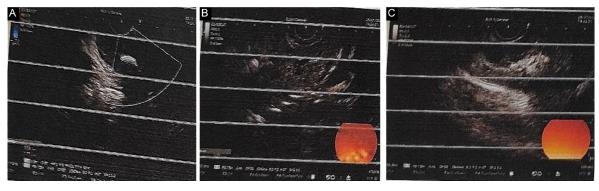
Endoscopic ultrasound report: Caroli's disease with PD calculi
